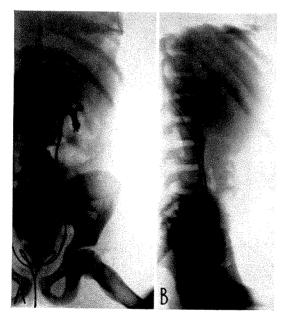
1, slight horizontal rotation. Spasm and irregular contraction of upper end of ureter. Small amount of gas in small bowel. B, slight anterior displacement of kidney and ureter, rotation chiefly horizontal. Roentgen diagnosis was perinephric infection but in addition there was a subcapsular abscess which was not diagnosed from roentgenogram.
